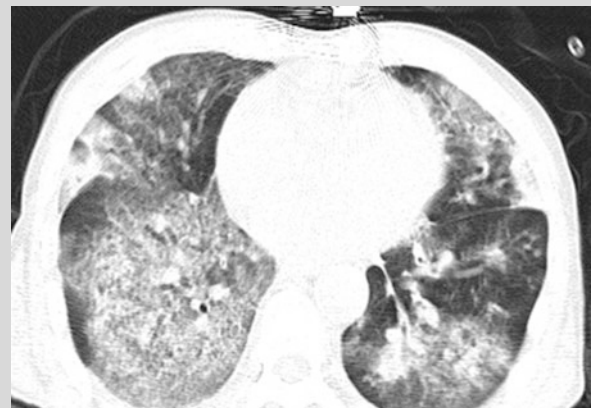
Chest CT scan showed ground glass opacity and patches of high density opacity in both lungs, with local consolidations
